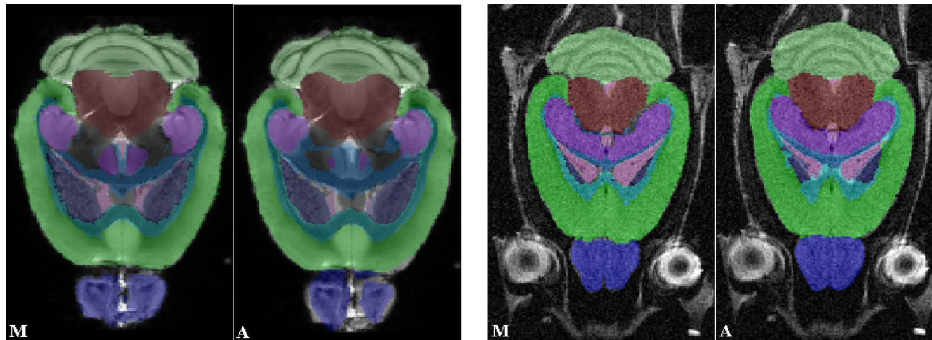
A visual comparison between the manual (M) and automated (A) segmentation for *in vivo* MRI (left) and *ex vivo* MRI volumes (right). The colour-coding of the various classes correspond to the legend as given in figure 4.2.
